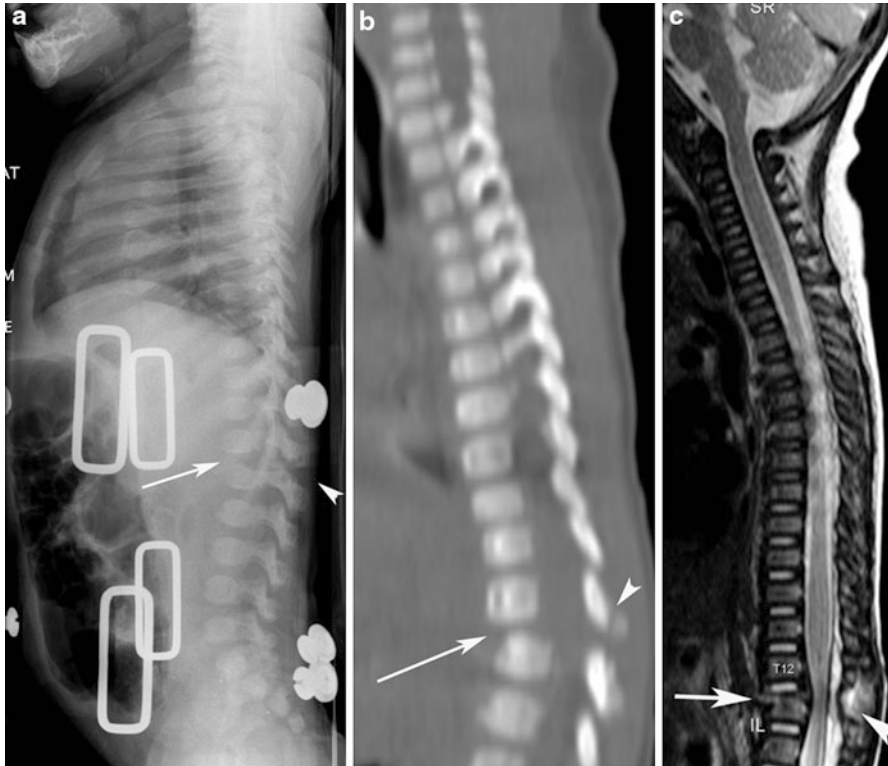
(a): A 4-month-old female showing compression fracture of L1 vertebral body with grade 1 spondylolisthesis of T12 on L1 (*arrow*) and increased interspinous distance between T12 and L1 vertebrae (*arrowhead*) indicating ligamentous injury. (b): Sagittal CT image better shows the alignment abnormality (*arrow*) and spinous process avulsion fracture (*arrowhead*). (c): Sagittal T2-weighted image with fat suppression showing the vertebral body compression fracture (*arrow*) and increased signal (*bright area*) in the interspinous region between T12 and L1 vertebra indicating edema from interspinous ligamentous injury/tear (*arrowhead*)
